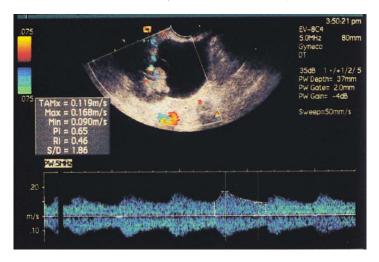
Transvaginal sonography of an endometroid adenocarcinoma with solid papillary projection within an endometrioma. Color Doppler imaging and spectral flow analysis reveal low-resistance flow within this solid projection.
